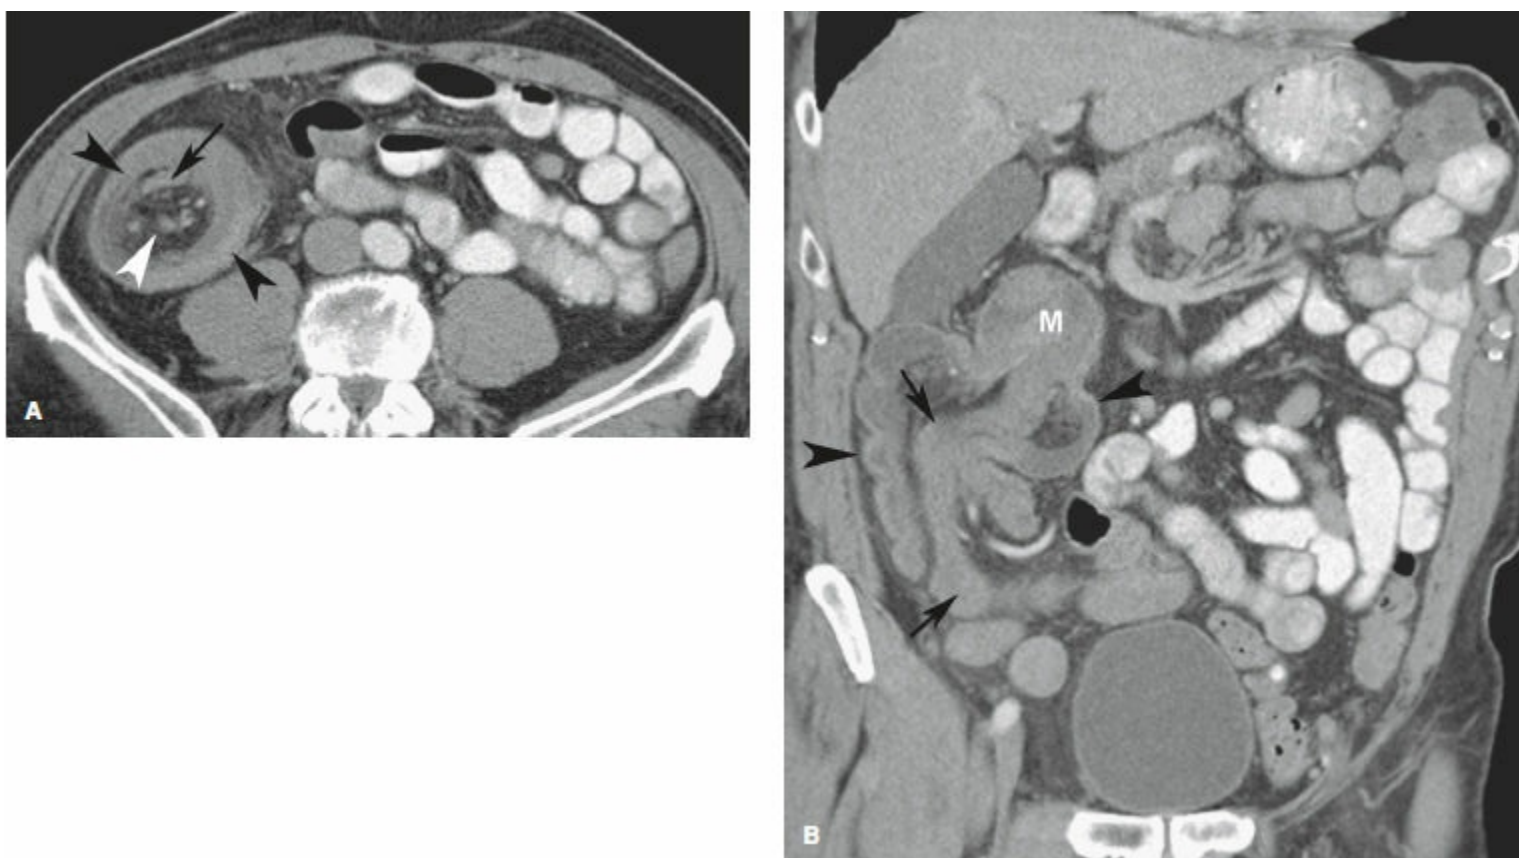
Axial (A) and coronal CT scan (B) images of an ileocolic intussusception secondary to colon carcinoma (M) as a lead point. Intussusceptum (*long arrows*) and intussusciens (*arrowhead*). Mesenteric vessels and fat (*white arrowhead*) accompany the intussusceptum.
